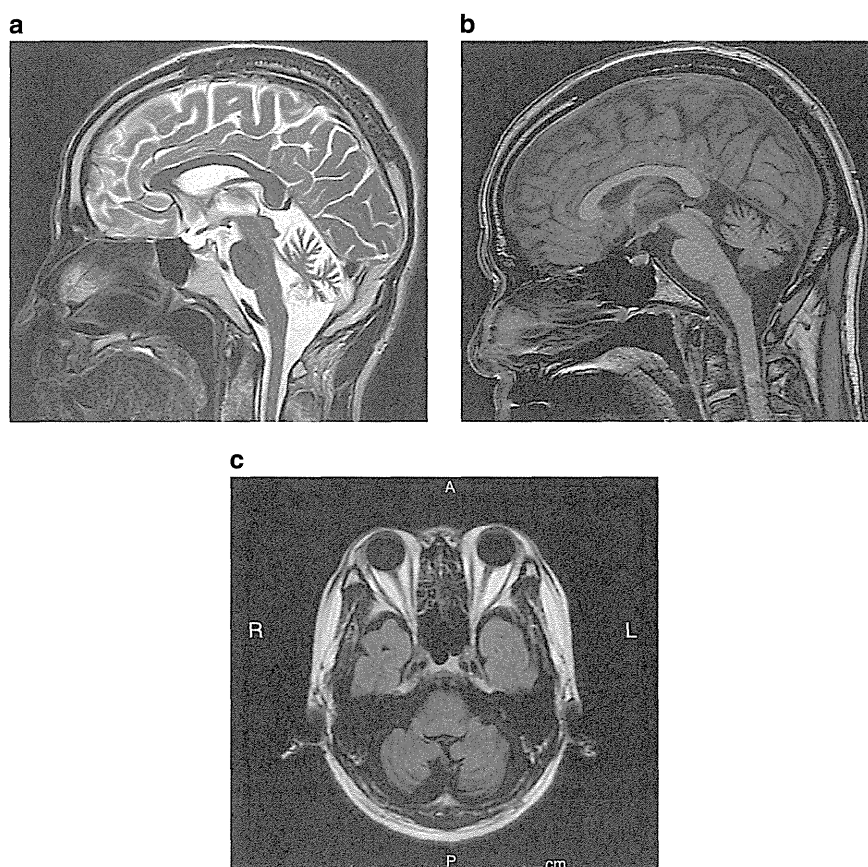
Representative brain MRI findings in the patients. Sagittal brain MRI of III-12 (a, T2-weighted) and III-15 (b, T1-weighted), and axial brain MRI of III-15 (c, T1-weighted) show moderate to severe cerebellar atrophy.
